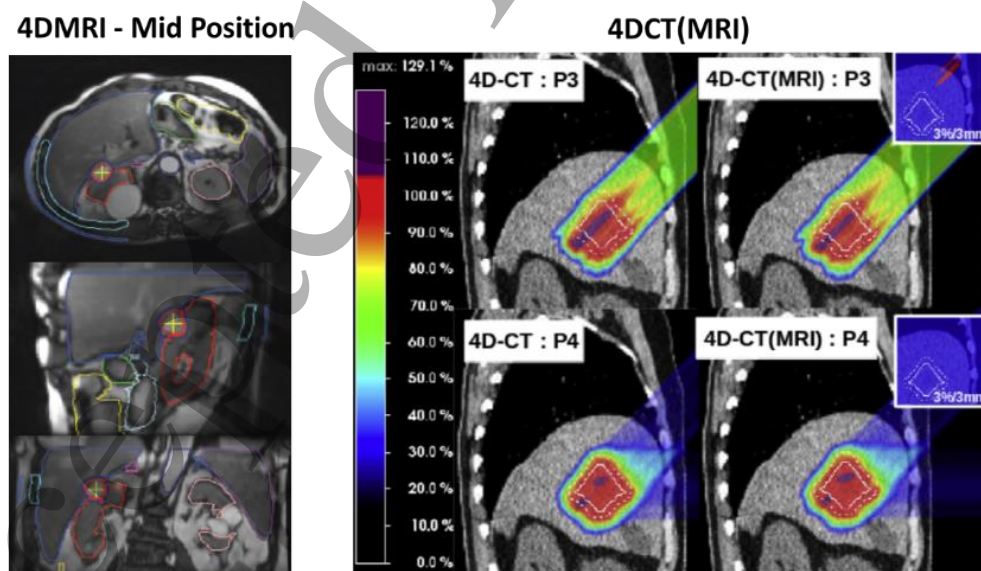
4DMRI in treatment planning. 4DMRI acquisitions with contours defined on the Mid Position on the left [reprinted with permission from (Stemkens et al. 2017)]. 4DCT vs. 4DCT(MRI) approaches for proton dose calculation on the right [reprinted with permission from (Bernatowicz et al. 2016)].
